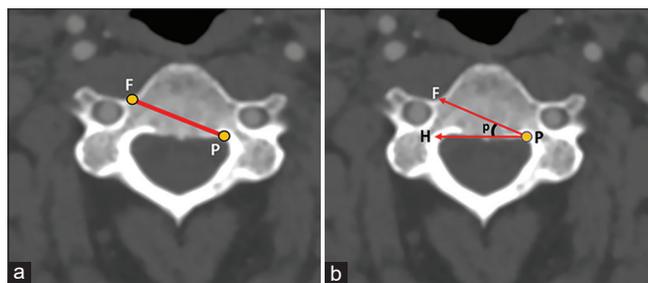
Measurement methods of F-P distance and p angle. (a) Axial CT-angiography scan shows F point, P point and measured line of the distance between them, (b) Axial CT-angiography scan shows the measurement of P angle between F-P line arm and a horizontal arm running through P point. CT - Computed tomography, F - Foraminal, P - Pedicular
